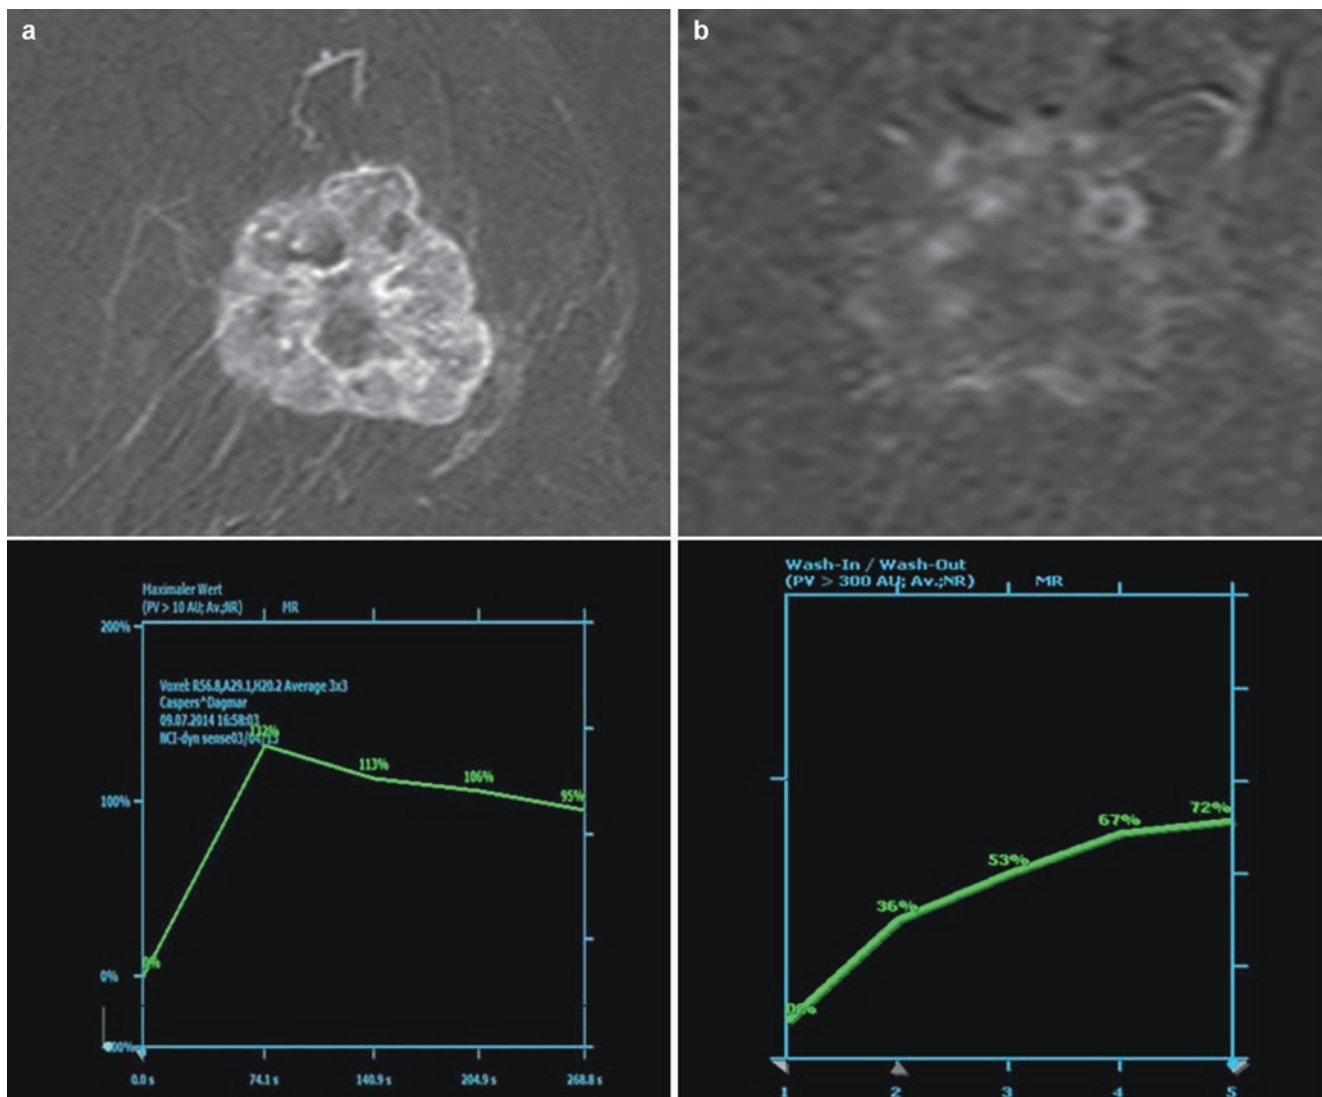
DCE-MRI for response assessment: Note strong and early enhancement with washout time course at baseline and slow enhancement
